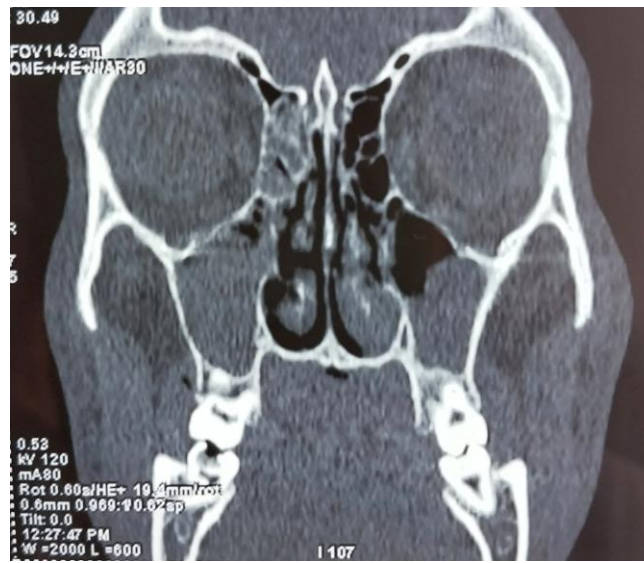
Computed tomography of the sinuses: mucosal thickening
